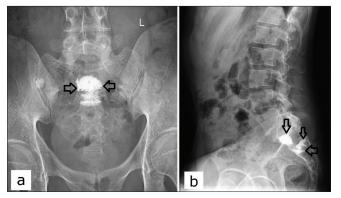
Postoperative X-ray image after 1 month. (a) Anteriorposterior view. (b) Lateral view. The bone cement is distributed along the transverse fracture line, mostly in the superior endplate of S2 and the anterior part of S1 which had a discrete fracture line on the preoperative computed tomography and magnetic resonance imaging. The arrows point to the bone cement distribution along the fracture line which is shown to be mostly in the transverse and oblique plane (the bottom part of the U-shape that is prone to the largest axial load).
